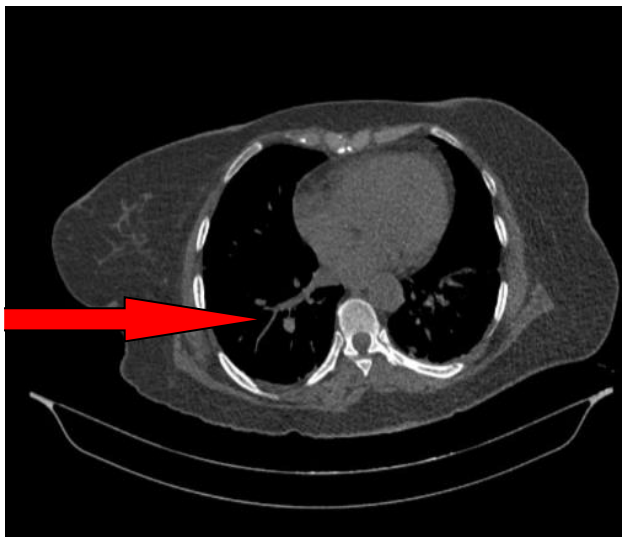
CT pulmonary angiography (axial view) showing an acute thrombus in the segmental and subsegmental branches of the right descending pulmonary artery, affecting the posterior basal segment of the right lower lobe.
